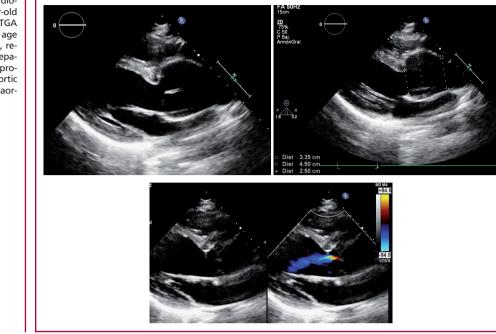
Color Doppler echocardiographic images of a 17-year-old patient with history of simple TGA operated on at one year of age with arterial switch procedure, requiring prior left ventricular preparation. Sixteen years after the procedure he presents with neo-aortic root dilation (Z=4.5) and mild aortic requrgitation.
